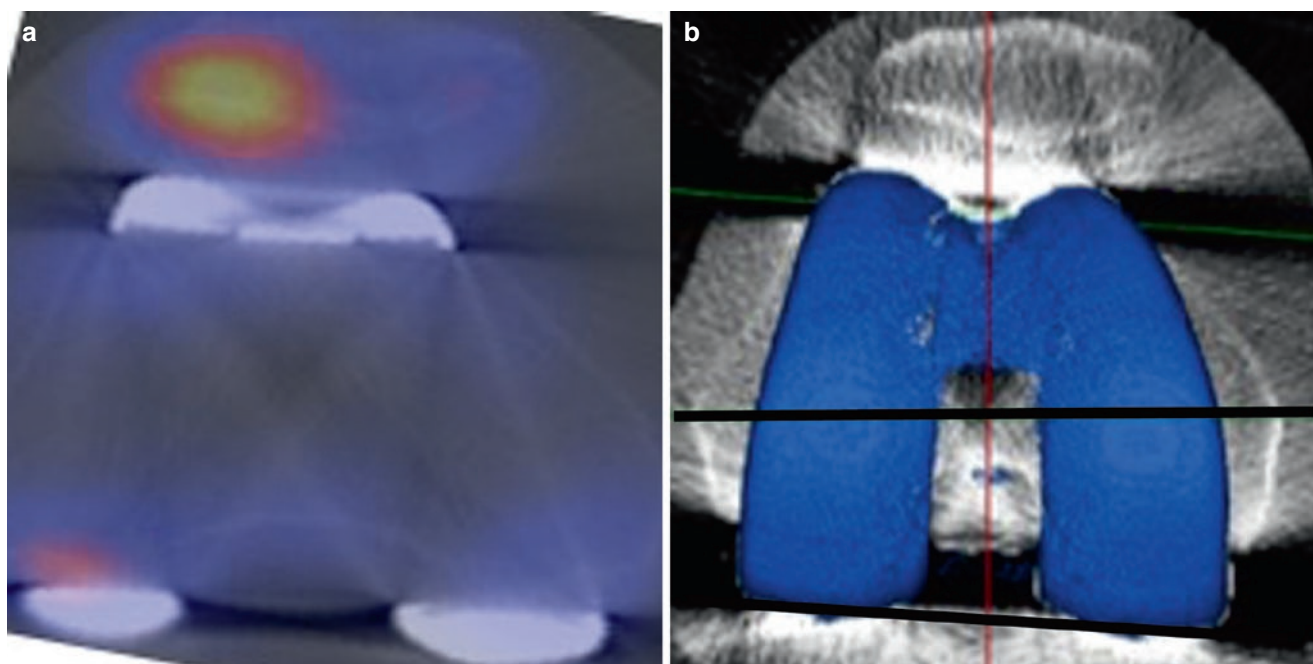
72-year old female with persistent pain 2 years after total knee arthroplasty. Axial image of the SPECT/CT (a) shows increased bone tracer uptake in the lateral patellar facet and posterolateral femur.
